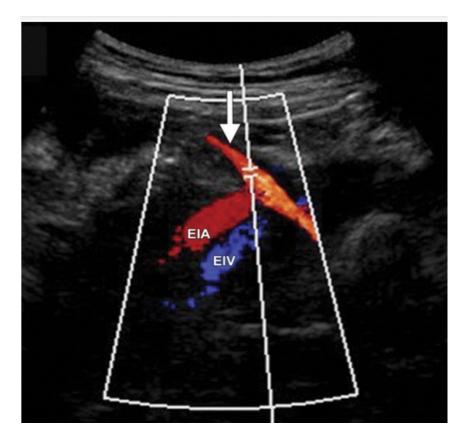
Color Doppler flow showing sample volume placed in the uterine artery
